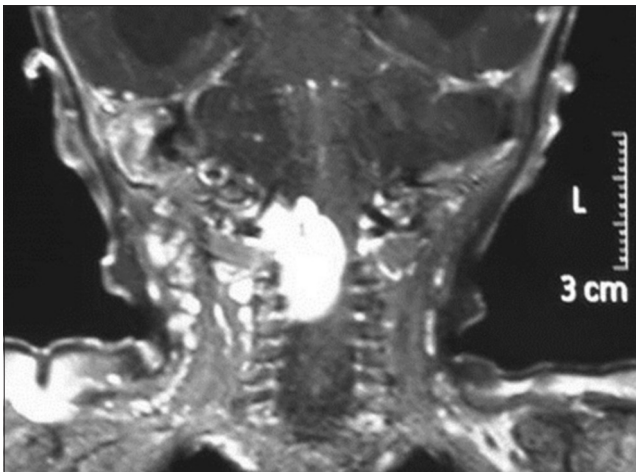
Magnetic resonance imaging on T1 weighted sequence in coronal section showing a hyperintense well circumscribed mass ranging from C2 to C3 extending through the right neural foramina of C2 and C3
